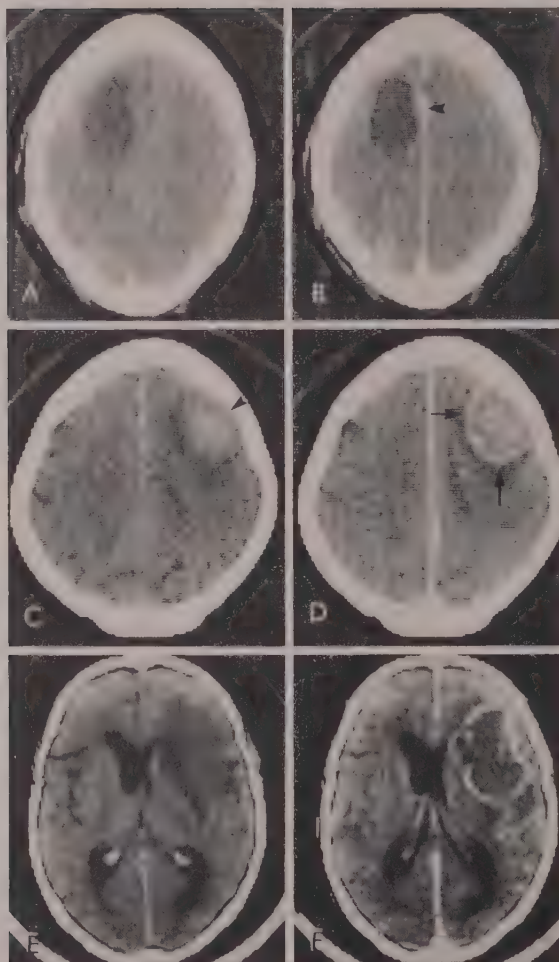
Ring Blush of Diverse Etiologies. Compare figures 8D, 11 and 24A. A and B, Astrocytoma. A, NCT reveals a homogeneously lucent mass. B, CECT shows a thin nearly even ring blush with slight thickening medially (arrowhead) along the falx. C and D, Dense hematoma in a 66 year old woman with thrombosed arteriovenous malformation. C, NCT 2 weeks after an acute hemorrhage reveals diminished density in the aging hematoma (arrowhead), surrounding lucent edema, and no significant mass effect. D, CECT reveals a slightly thick ring blush (arrows) circumscribing the hematoma. The ring blush of hematoma is usually situated exactly at the edge of the hemorrhage. E and F, Resolving lucent hematoma in a 73 year old man with known carcinoma of the prostate and pelvic lymph node metastases. E, NCT reveals a large lucent mass and midline shift. F, CECT shows a thin lobulated ring blush. Surgerv, pathology and serial follow-up CT scans revealed no evidence of neoplasm.
